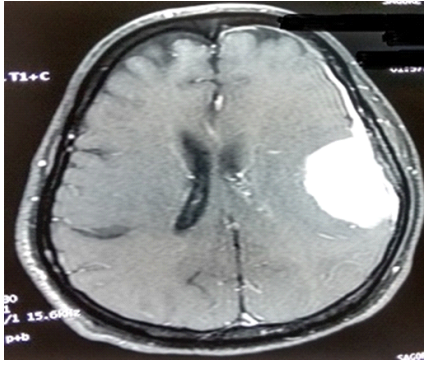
MRI Contrast axial image showing Left sided convexity meningioma.
